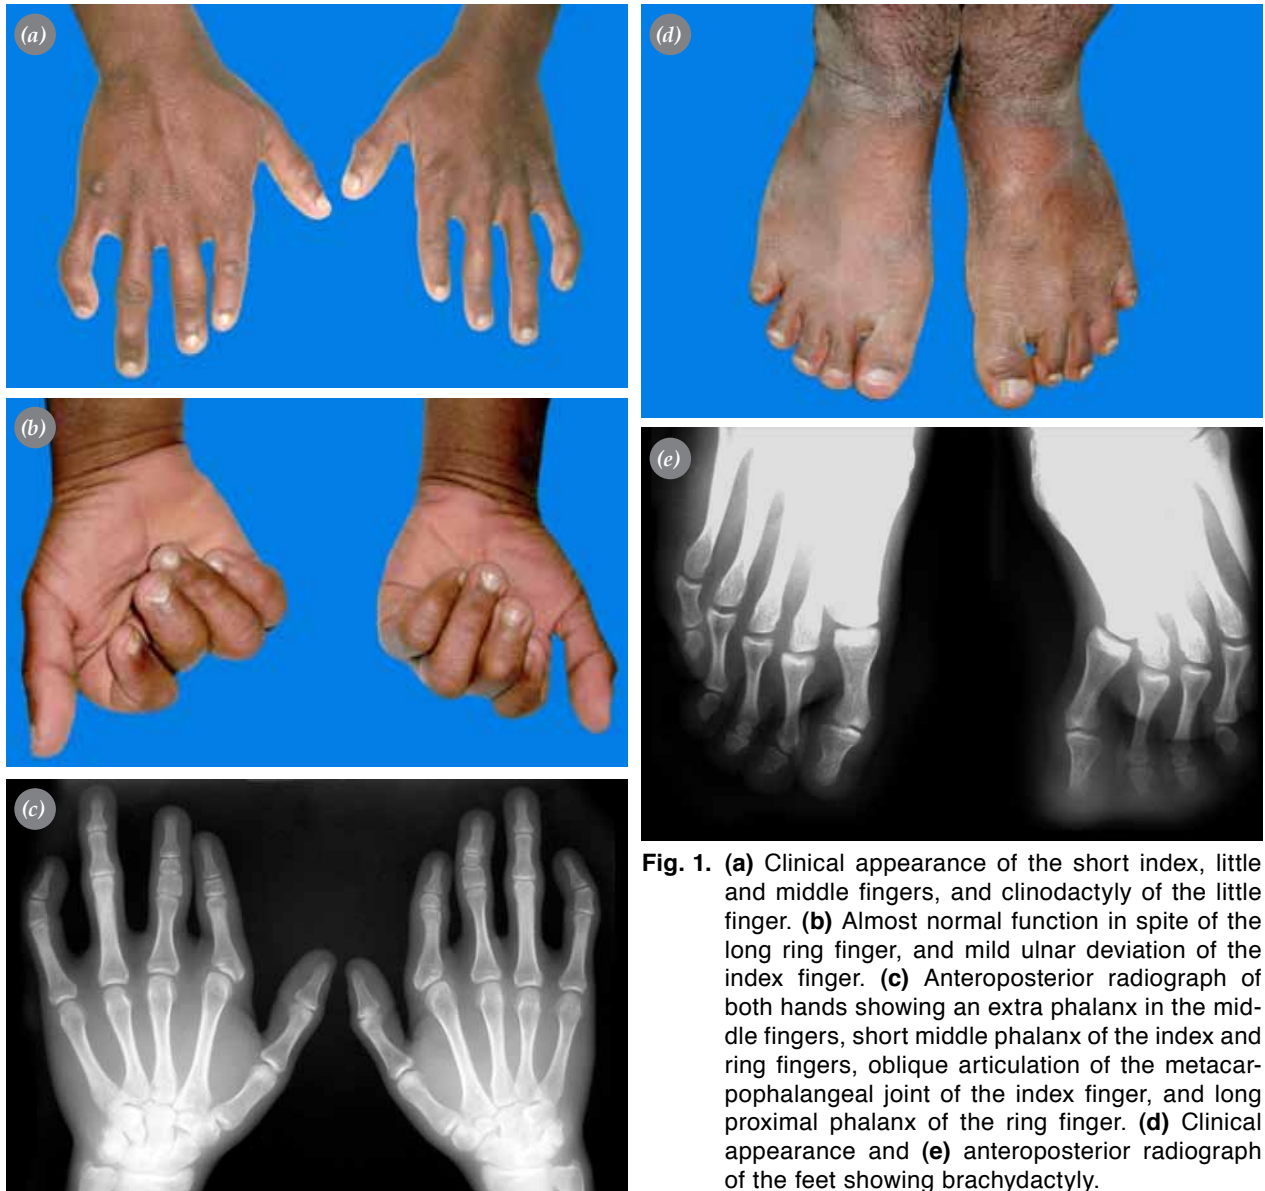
(a) Clinical appearance of the short index, little and middle fingers, and clinodactyly of the little finger. (b) Almost normal function in spite of the long ring finger, and mild ulnar deviation of the index finger. (c) Anteroposterior radiograph of both hands showing an extra phalanx in the middle fingers, short middle phalanx of the index and ring fingers, oblique articulation of the metacarpophalangeal joint of the index finger, and long proximal phalanx of the ring finger. (d) Clinical appearance and (e) anteroposterior radiograph of the feet showing brachydactyly.
